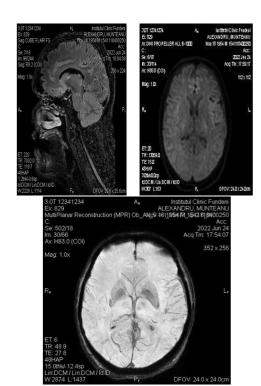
MRI performed after treatment shows disease regression. Until now, (6 months after the diag-nosis of myelomatous meningitis), the patient has a partial remission of the disease, with the remission of neurological symptoms and good quality of life. Six intrathecal appli-cations, five courses of Daratu-mumab-Pomalidomide-Dexame-thasone, and craniospinal radiotherapy were performed, without major complica-tions secondary to treat-ment administration. Although the evolution of the disease is not long, only 4 years until now, the complica-tions, both related to the treatment and the disease, were multiple, posing important problems in the management of the case.
